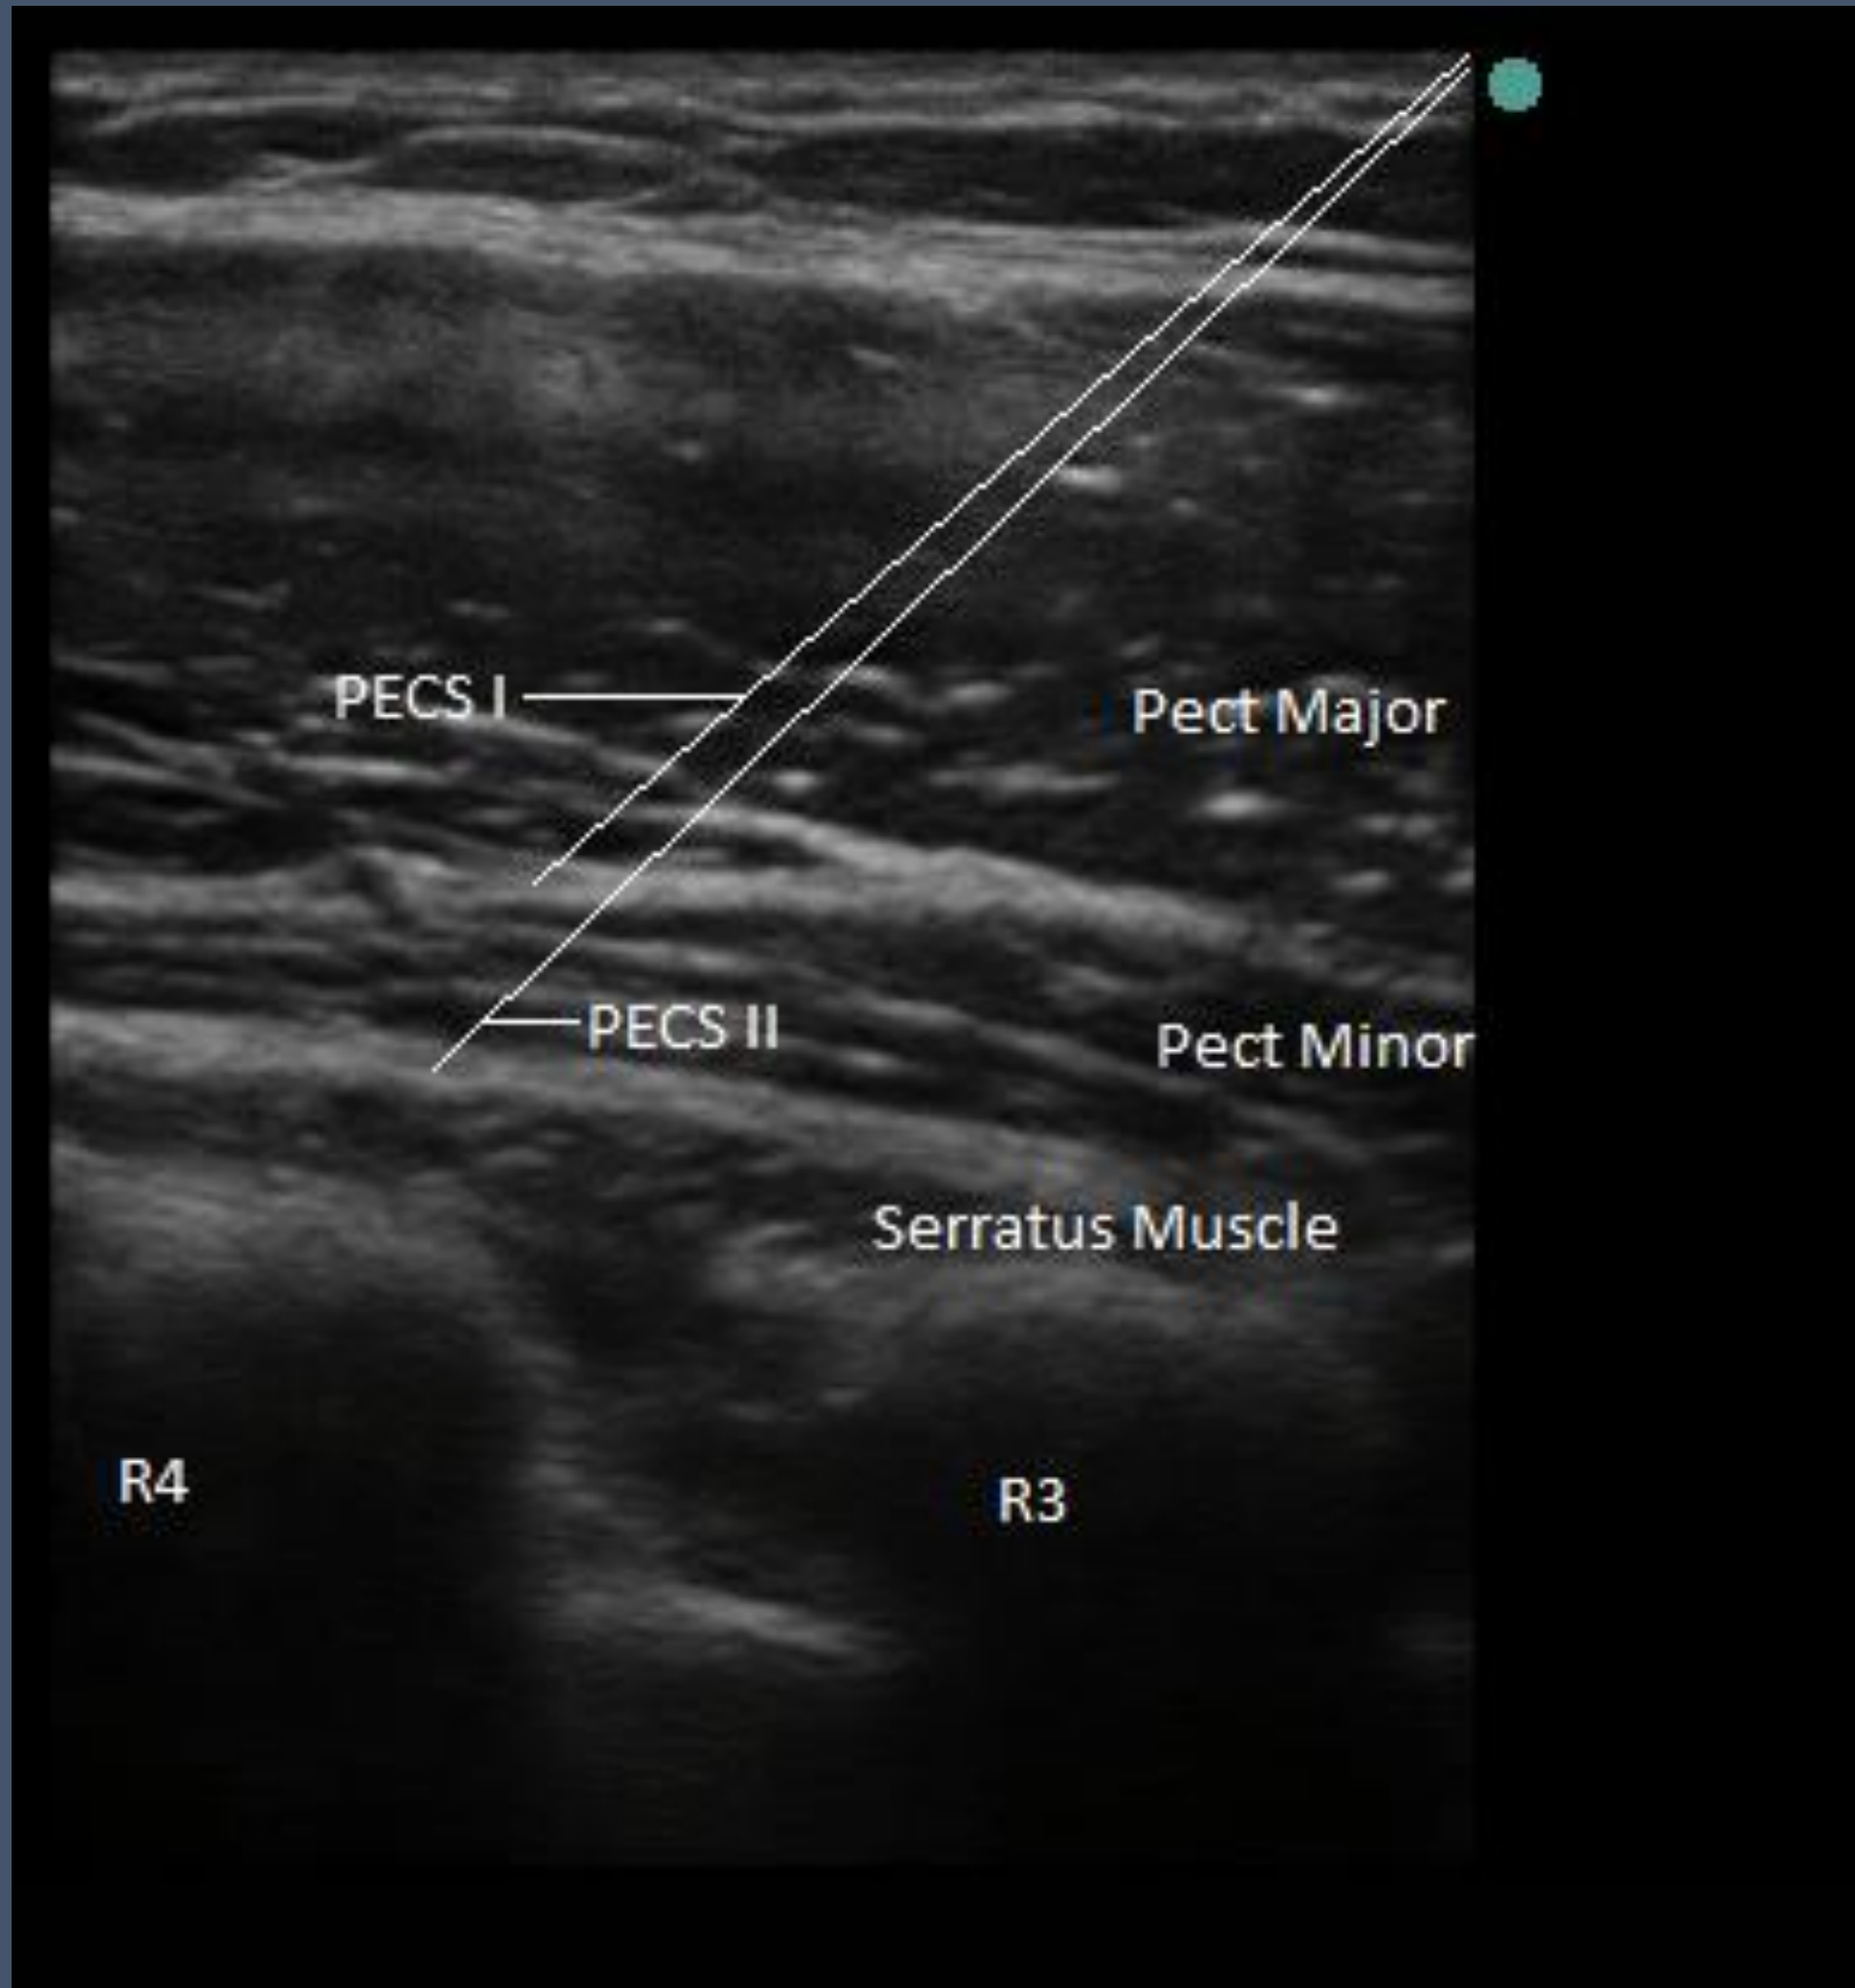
Ultrasound image describing PECS II block in anatomically normal patient (Ortiz).
